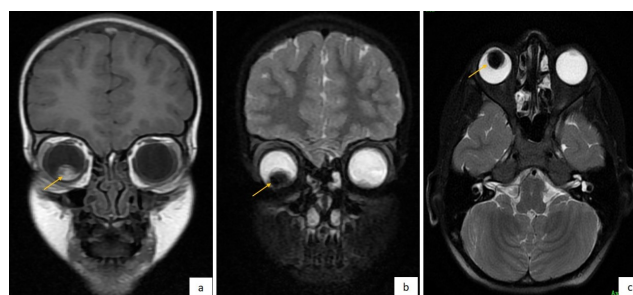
Magnetic resonance imaging showing, a hyperintense mass lesion on T1 weighted image in the coronal section (a) and hypointense mass on T2 weighted images in the coronal and axial sections (b,c).
